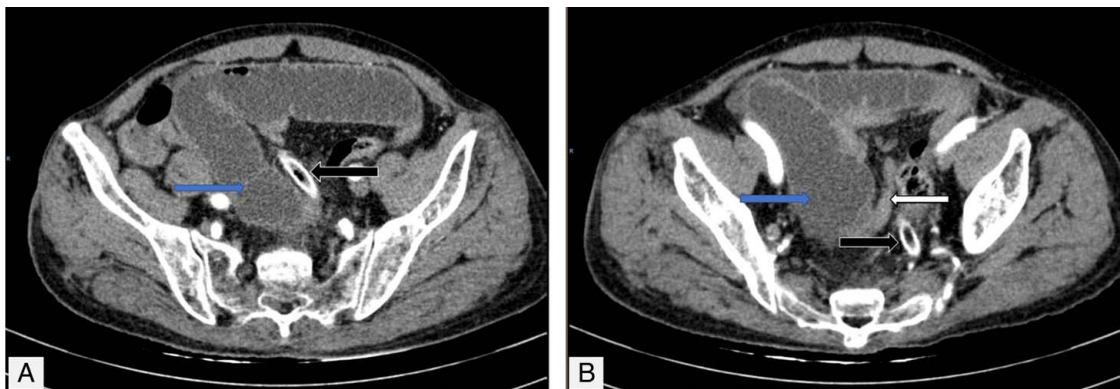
Contrast-enhanced axial computed tomography (CT). The dilated loop of the small bowel (blue arrow), the drainage sonde (black arrow), and the collapsed bowel loop below the transition zone (white arrow). (A) CT showed a 47-mm dilated loop of the bowel proximal to the drainage sonde and the sonde position at the transition site. (B) The image revealed the dilated bowel loops continued with collapsed ones at the transition site.
